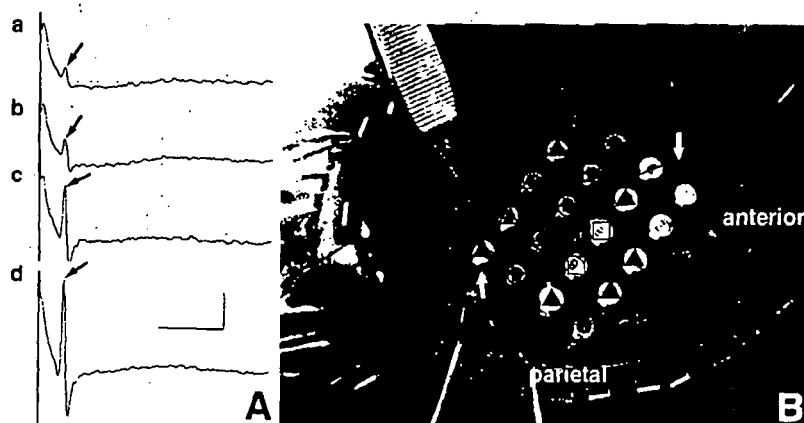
A: Representative D-waves (arrows) classified into amplitudes of under $2\ \mu\text{V}$ (a), 2 to $5\ \mu\text{V}$ (b), 5 to $10\ \mu\text{V}$ (c), and over $10\ \mu\text{V}$ (d). Time scale, 5 msec; amplitude, $5\ \mu\text{V}$. B: Photograph of the intraoperative epidural grid electrode placed over the sensory, primary motor, and premotor cortices in Case 1. The amplitude of the D-wave evoked by the stimulation of each plate electrode was classified as over $10\ \mu\text{V}$ (open circles), 5 to $10\ \mu\text{V}$ (open squares), 2 to $5\ \mu\text{V}$ (open triangles), and under $2\ \mu\text{V}$ (closed triangles). Thick line: Central sulcus estimated by magnetic resonance imaging-guided navigation.
